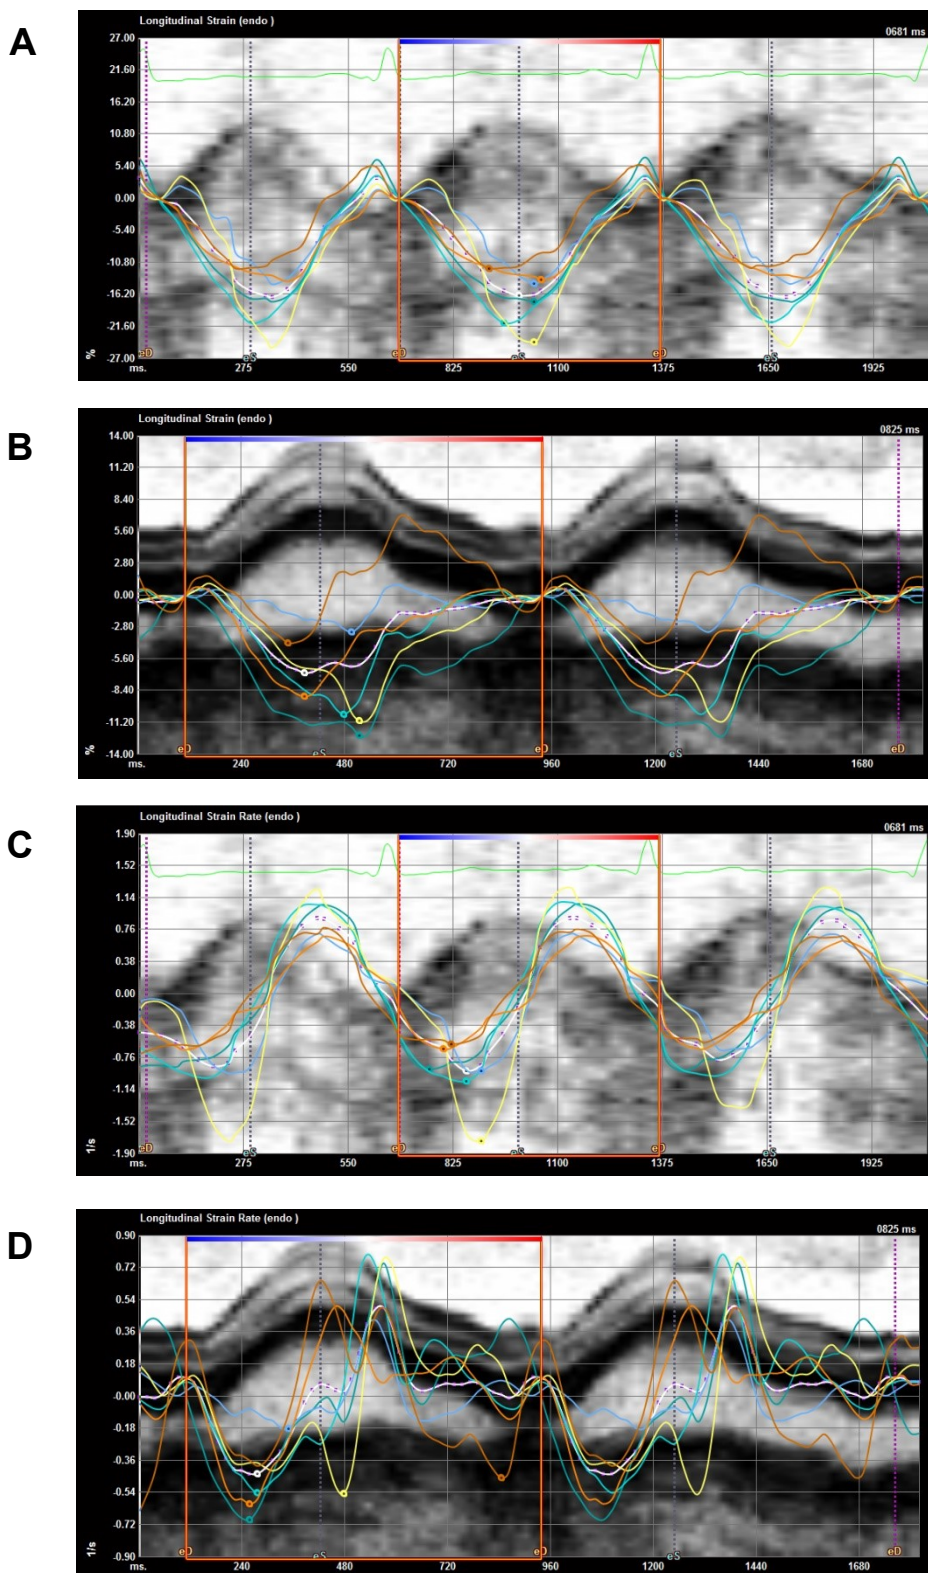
Examples of endomyocardial strain- and strain-rate curves. Different segments in apical two chamber view measured with 2D-CPA using the software TomTec.
